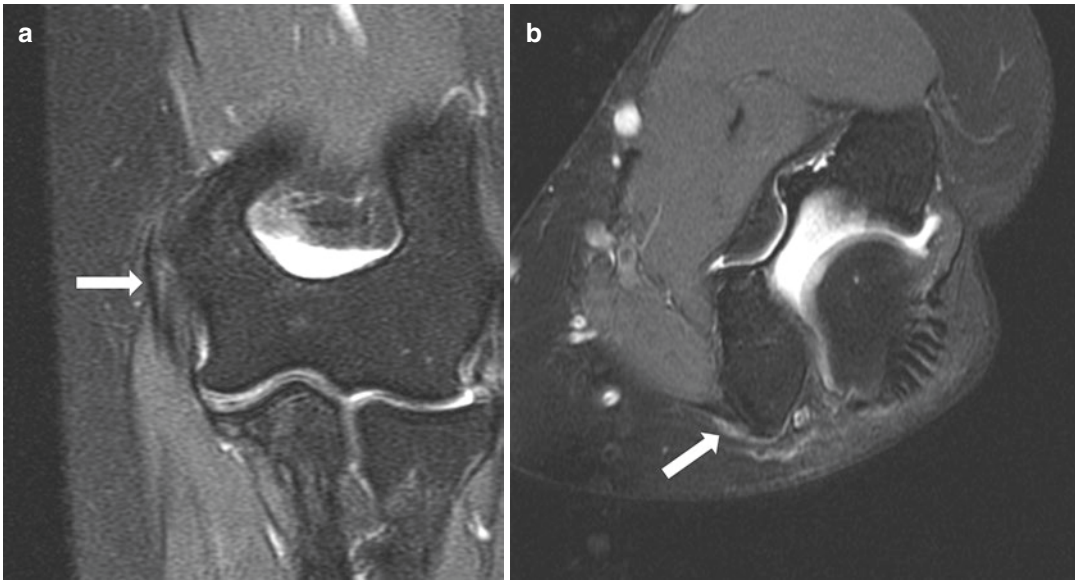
Coronal (a) and axial (b) T2 FSE MR images with fat saturation demonstrating mild increased signal and focal enlargement of the flexor carpi radialis origin compatible with mild tendinopathy (arrows)
